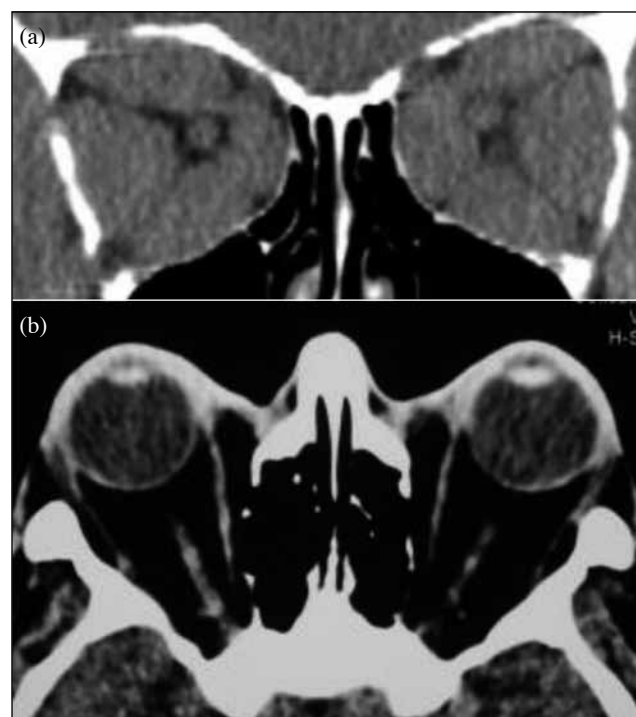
Coronal computed tomography of the orbits showing (a) diffuse and symmetric extraocular muscle enlargement with apical compression on the optic nerve, and (b) symmetrical severe proptosis and straightening of optic nerves with expansion of the orbital fat compartment and minimal muscle involvement in a young female non-smoker with thyroid eye disease.
